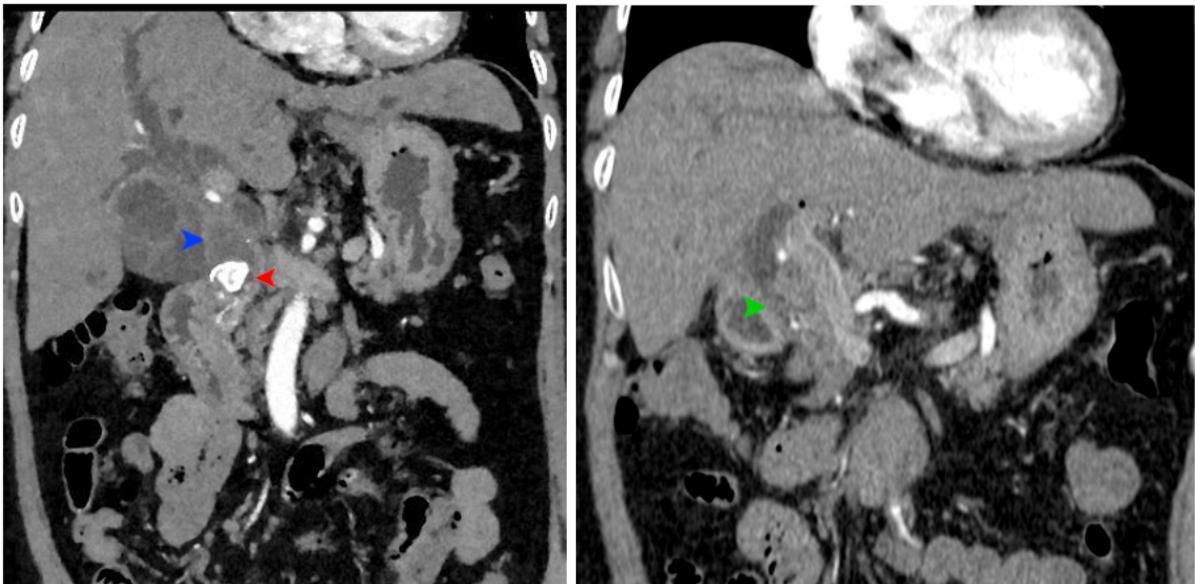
Left: CT-Scan of the abdomen at diagnosis, showing bile stone (red arrow) in common bile duct with a mass lesion proximal to the stone (blue arrow). Right: CT-Scan performed 1-month post chemotherapy, showing no sign of residual tumor (green arrow).
